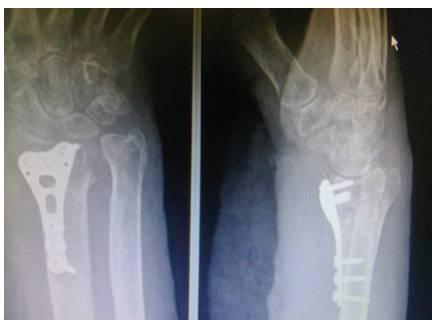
Radiographs of patient P., 74 years after surgical treatment
